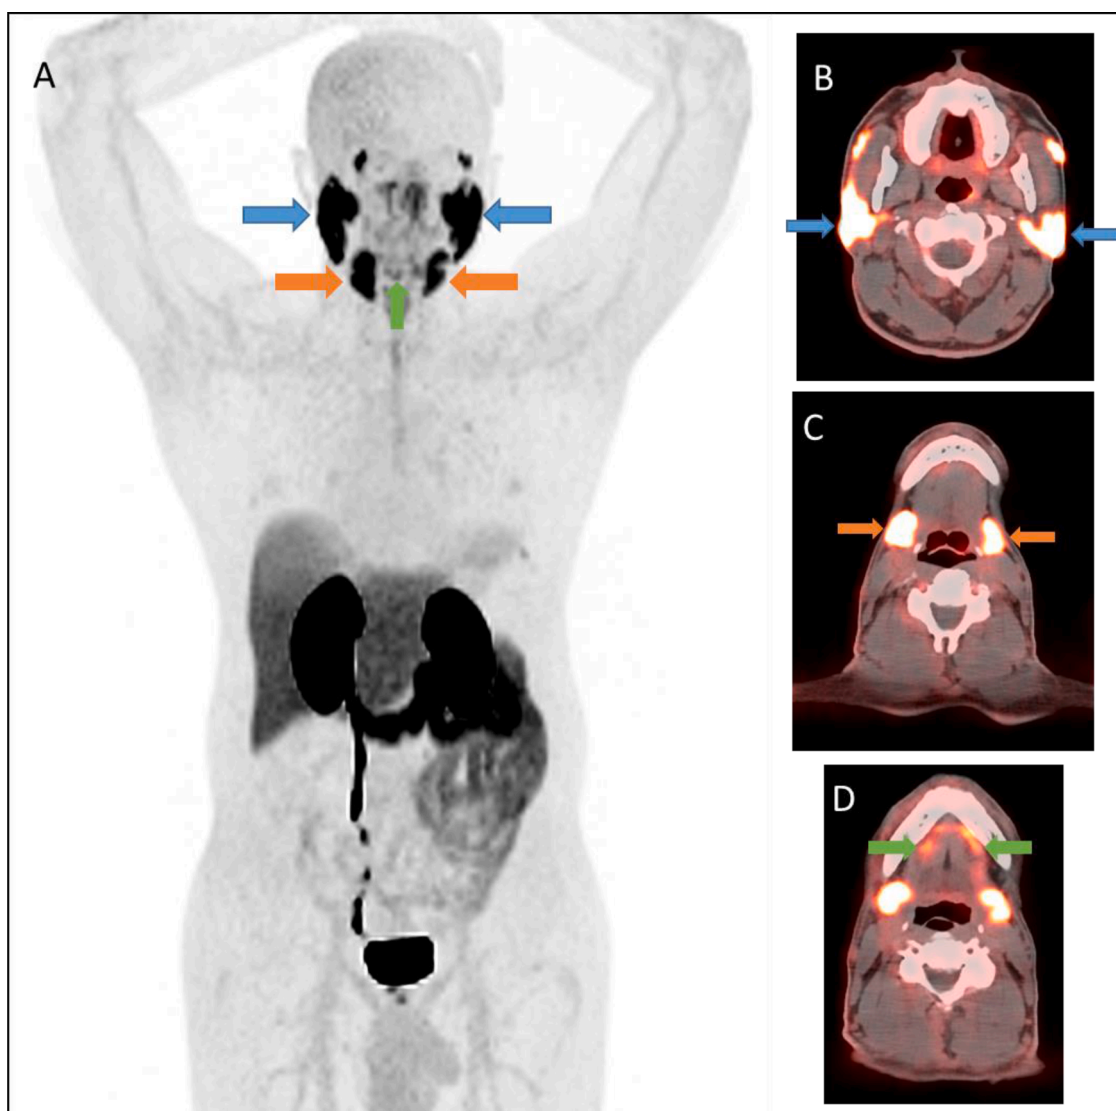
Concentration of PSMA-ligand in major salivary glands. (A) Maximum-intensity projection image of ^{18}F -Piflufolastat PET/CT, with (B, blue arrows) Fused PET/CT images at the level of parotid glands, (C, orange arrows) at the level of submandibular glands, and (D, green arrows) at the level of sublingual glands.
